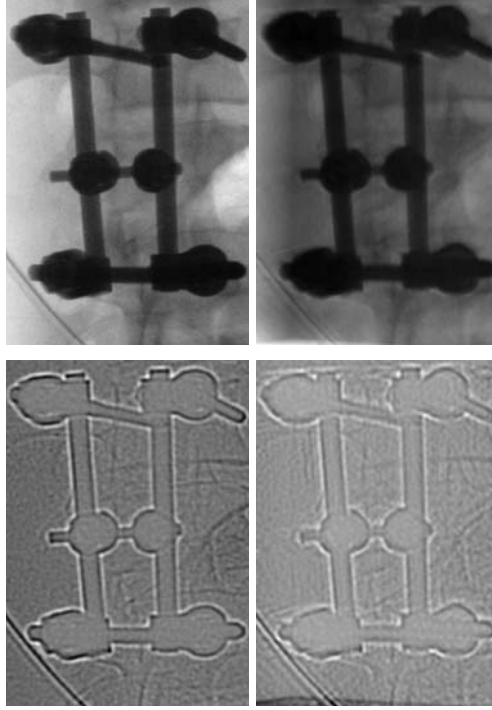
On the top left side a detail of the original CBCT scan and on the right the same area from the forward projection of the first reconstruction is presented. The two images below show the results of a edge filtering.
